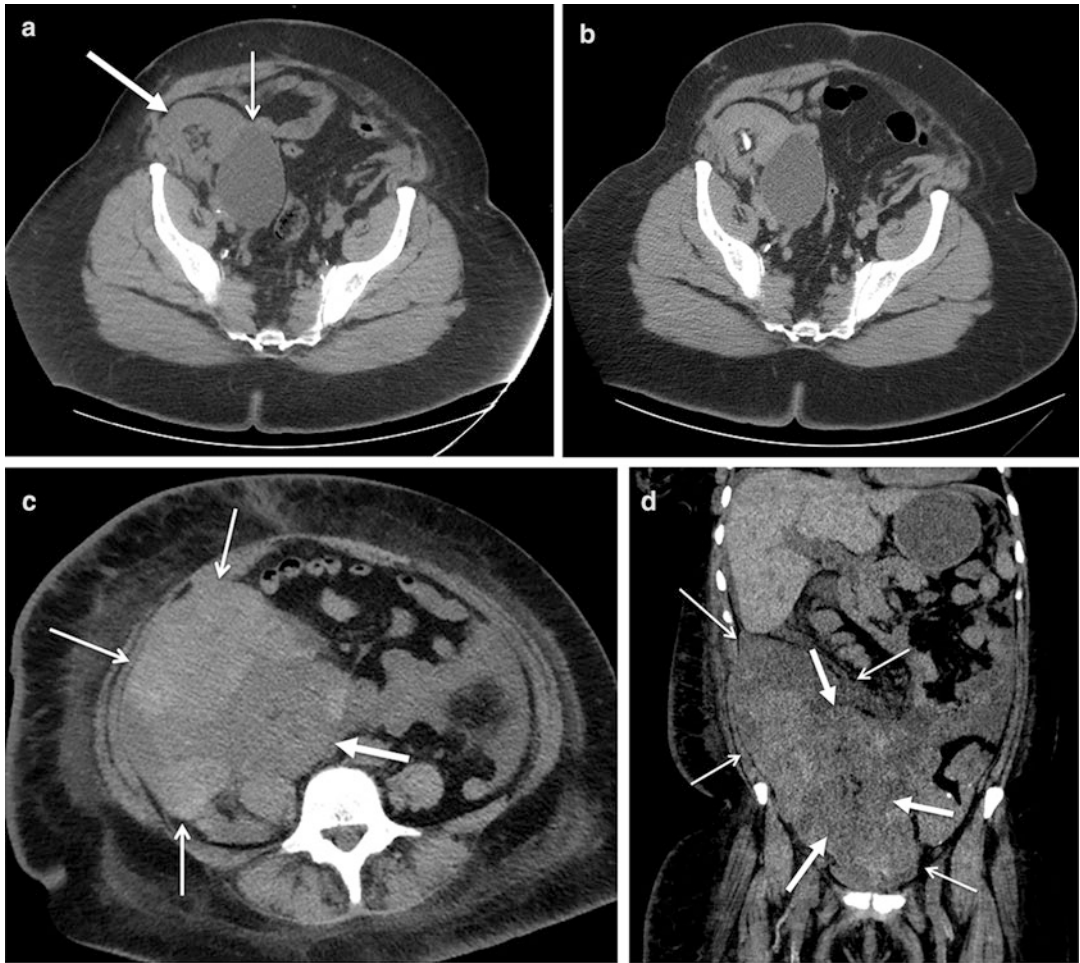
CT of posttransplant fluid collections. (a) The precontrast image shows an ovoid fluid collection (*arrow*) medial to the renal allograft in the right iliac fossa (*thick arrow*). (b) The corresponding postcontrast image demonstrates absent enhancement, confirming the absence of solid tissue and the cystic nature of this
